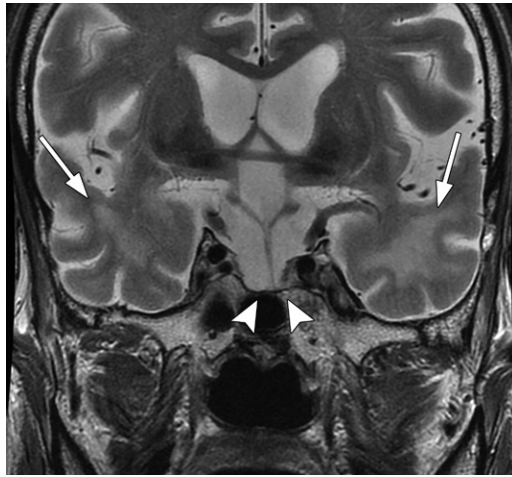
Atrophy of the pituitary gland and leukoencephalopathy in a 57-year-old man who underwent RT (standard-fractionation type) 30 years earlier for a pituitary adenoma. On a coronal T2-weighted image, the pituitary gland is markedly atrophic (arrowheads) and almost unidentifiable. The adjacent brain parenchyma (bilateral temporal lobes) is atrophic and exhibits hyperintense signal changes in the white matter (arrows), suggestive of radiation-induced leukoencephalopathy.
